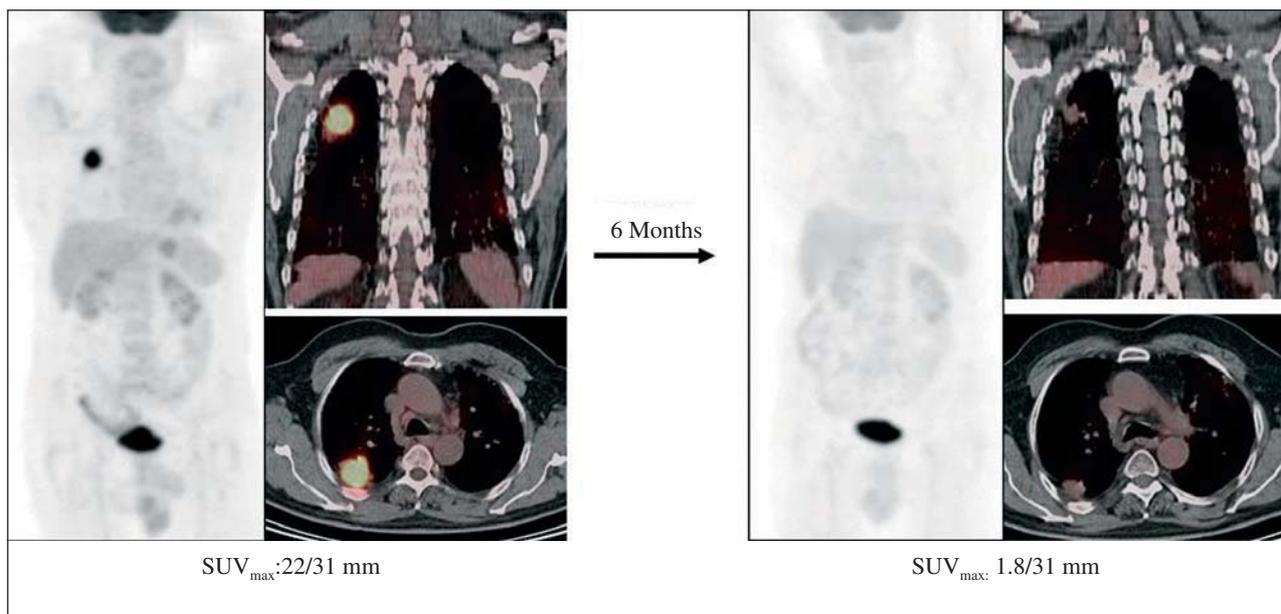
Evaluation of response to chemotherapy and radiotherapy in non-small cell lung cancer located in the upper right lobe. Positron emission tomography–computed tomography: reduction in size and marked decrease in metabolic activity of a neoplastic lesion in segment 2 of the right lung. SUV_{max} indicates maximum standard uptake values.
